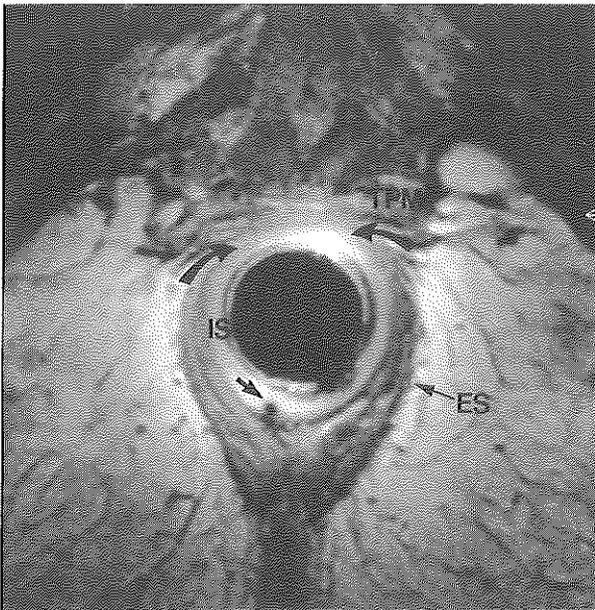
Endoanal MRI, axial proton density weighted GRE showing anterior a discontinuity of the external sphincter (ES) ring (curved arrows). This can be interpreted as a defect but is in fact a normal variant determined by the proximity of the transverse perineal muscle (TPM), which make the external sphincter fibers difficult to delineate. Internal sphincter (IS). Small coil artifact (arrow).
